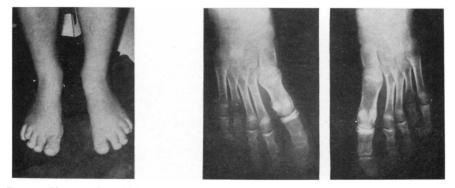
Photograph and X-ray views of the feet of case 2 demonstrating the marked shortening of the fourth metatarsal and toe.
